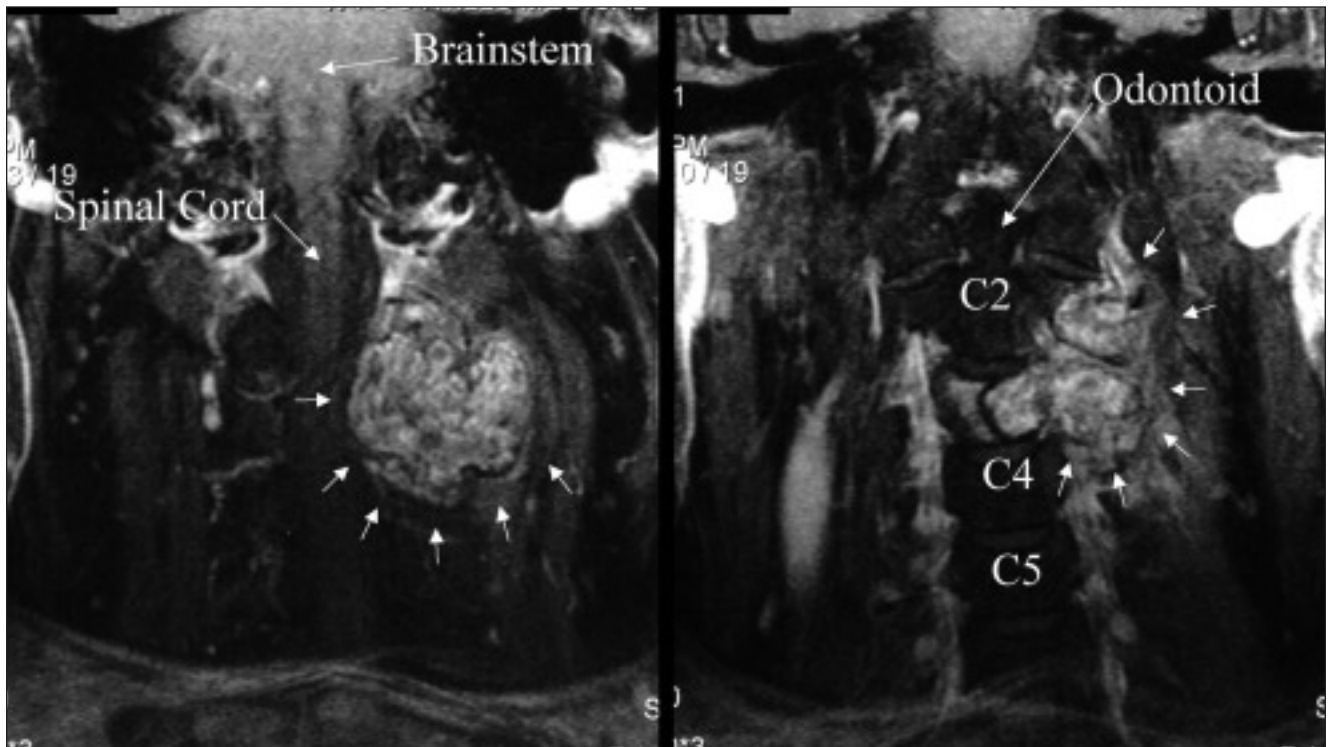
Gadolinium-enhanced magnetic resonance imaging reveals the extent of the aneurysmal bone cyst. Arrows encircle the lesion.
